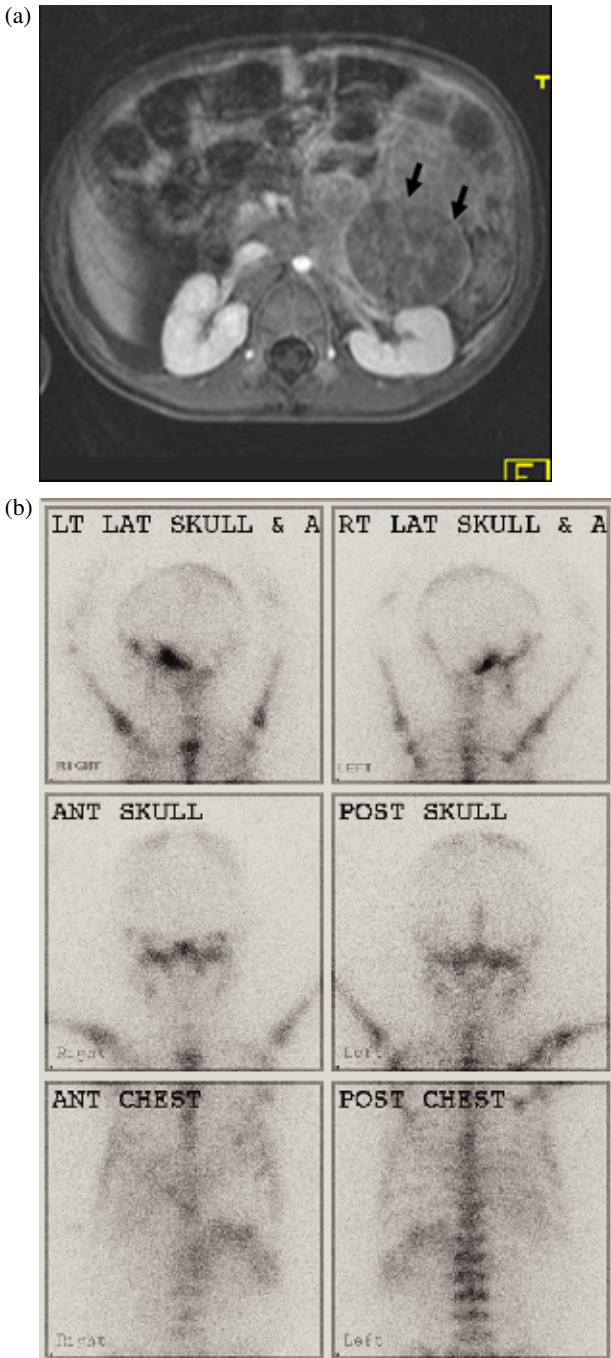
Imaging of a 2.5-year-old girl with skeletal pain and irritability. (a) Axial MRI T1W image with fat suppression and injection of gadolinium shows a rim-enhancing lesion of low signal intensity in the left retroperitoneum (arrows). (b) MIBG shows diffuse bone marrow uptake, which mimics the appearances of a bone scan, but indicates diffuse marrow infiltration. NBL stage 4.
